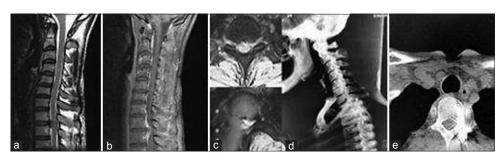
(a) T2-weighted sagittal magnetic resonance imaging (MRI) shows T1–T2 disc herniation. (b) Sagittal cervical fat saturated MRI shows the same. (c) Axial T2-weighted MRI shows a hyperintense disc on the left side. (d) Three-dimensional cervical computed tomography (CT) scan shows T1–T2 and T3 screw rod fixation on the left side. (e) Axial CT scan shows a pedicle screw in an upper thoracic vertebra.
